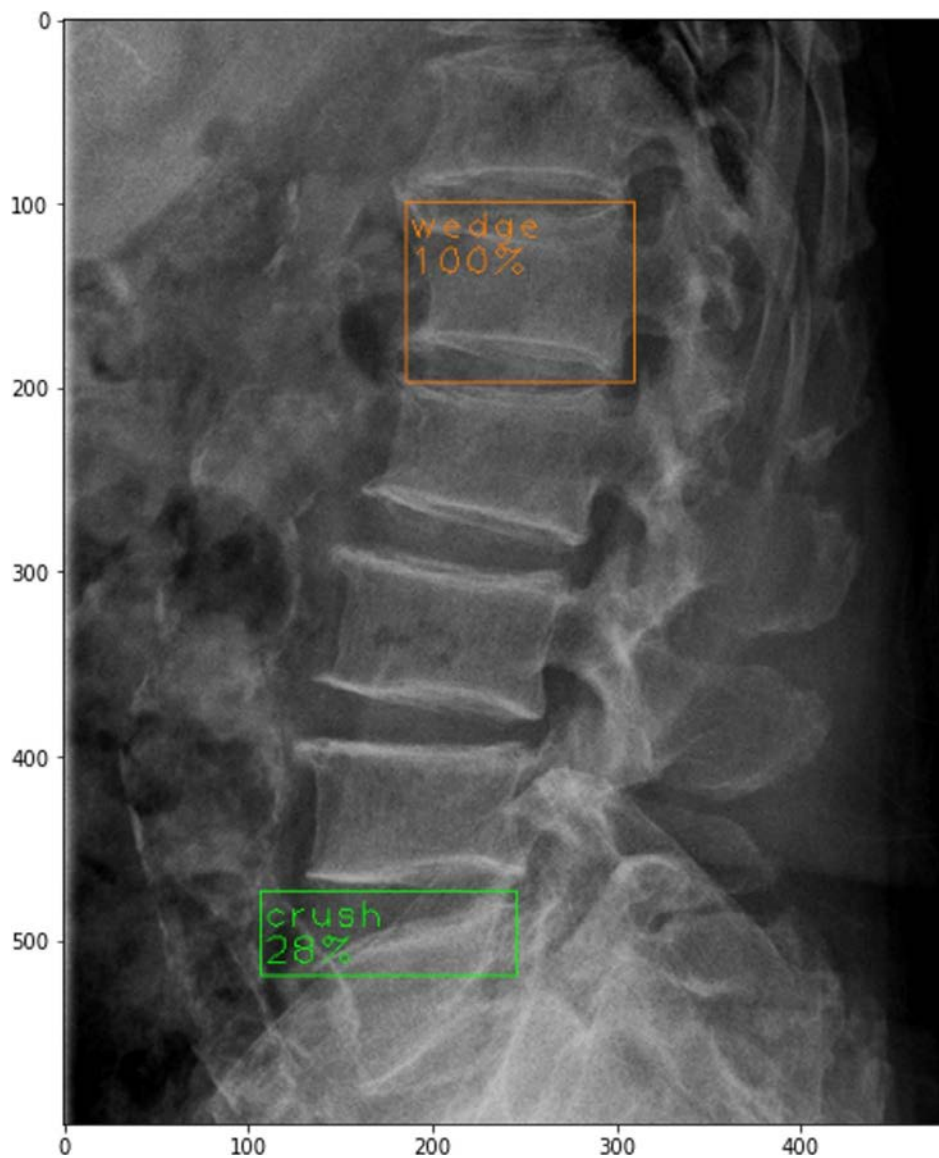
Objects detection of a lateral spine X-ray image. The threshold confidence is chosen 25% as a fixed level in the experiment.
